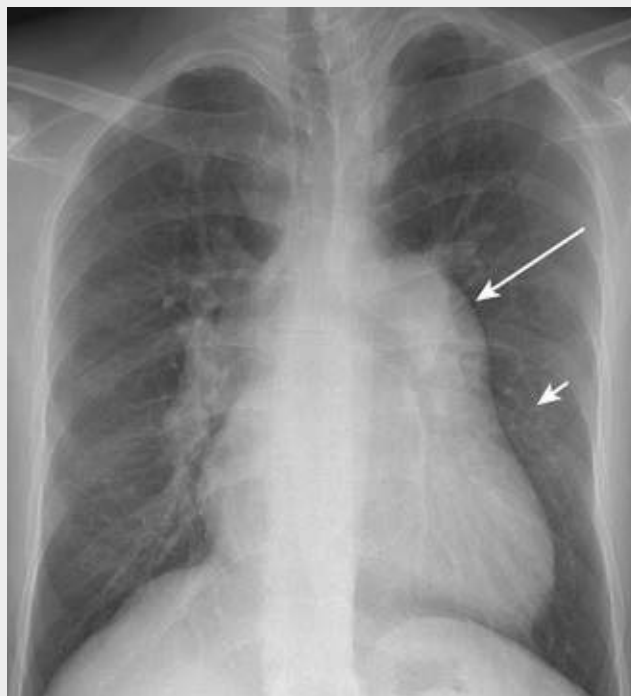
Congenital pulmonic stenosis. A, PA radiograph demonstrates marked enlargement of the main pulmonary artery (MPA) (*long white arrow*), such that it is larger than the aorta (*short white arrow*). Note that the right pulmonary artery and its branches are normal sized, and the enlarged left pulmonary artery (LPA) is hidden behind the dilated MPA. B, On the lateral view the retrosternal space is filled by the enlarged right ventricle and the dilated MPA, which causes a masslike density with an upward convexity (*long white arrow*). Note dilated LPA (*long black arrow*) relative to the aorta (*short white arrow*).
